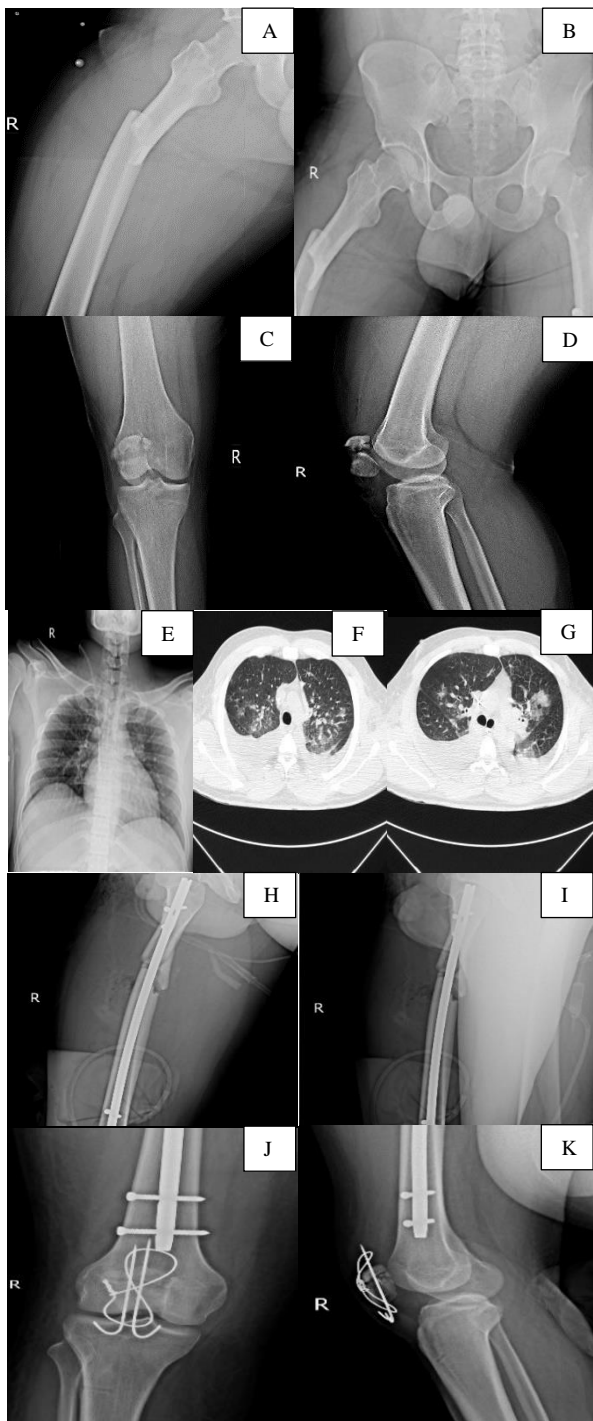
A-D) preoperative radiographs of the patient, E) chest X-ray, F and G) chest computed tomography (CT) scan, H-K) postoperative radiographs
